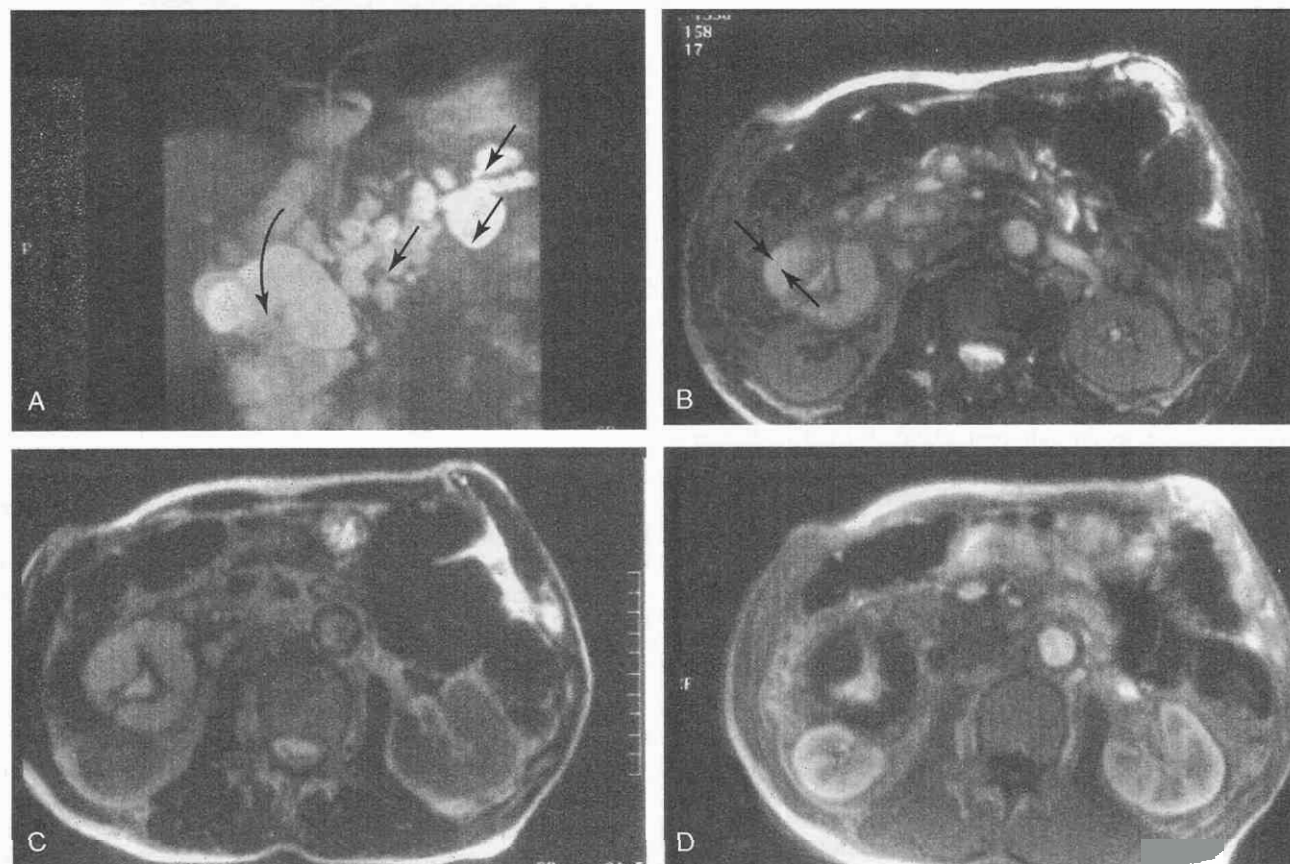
A, MR pancreatogram in a patient with an annular pancreas. The pancreatic duct is very dilated owing to chronic pancreatitis. Note the cystic enlargement of the duct in the body and tail (*arrows*) as well as the massive dilatation of the duct in the head. The head of the pancreas circumferentially surrounds the second portion of the duodenum (*curved arrow*). B, Axial image with true FISP sequencing, showing the dilated annular pancreatic duct (*arrows*), around the duodenum. C, Same image with T2 weighting. D, T1-weighted image obtained after instillation of gadolinium shows cystic duct and vascular enhancement. Courtesy of Elmer Merkel, University Hospitals of Cleveland.
